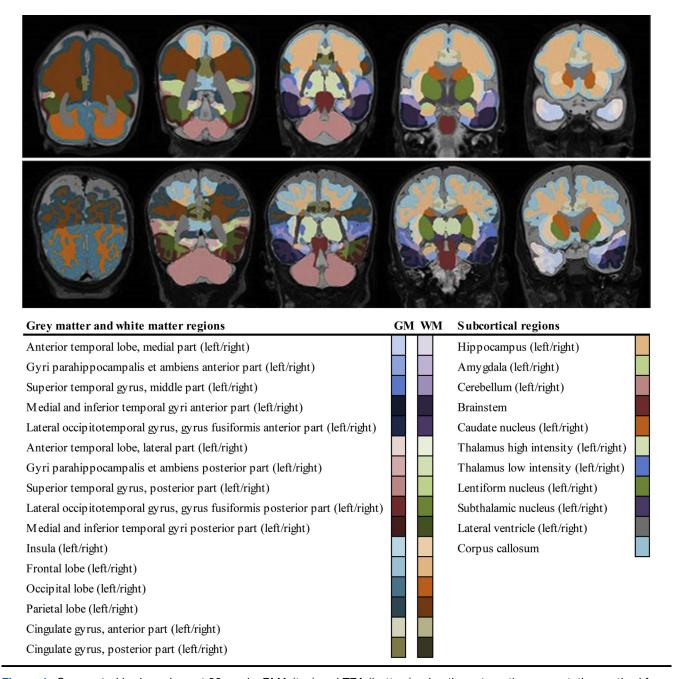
Segmented brain regions at 30 weeks PMA (*top*) and TEA (*bottom*) using the automatic segmentation method from Makropoulos et al 2014. ²⁵ The obtained T2-weighted images were segmented into 84 different tissue classes using an automatic segmentation method. ³⁴ This technique is highly accurate across a wide range of PMAs, from 24 weeks gestational age to TEA. *GM*, grey matter; *WM*, white matter.
